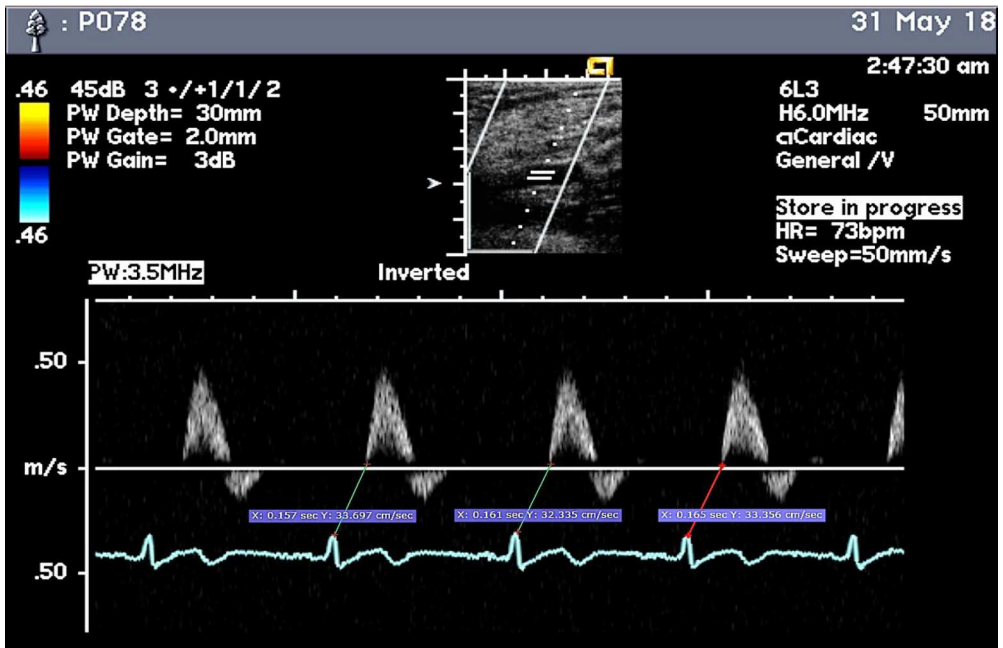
Doppler ultrasound of the pulse wave at the common femoral artery.
